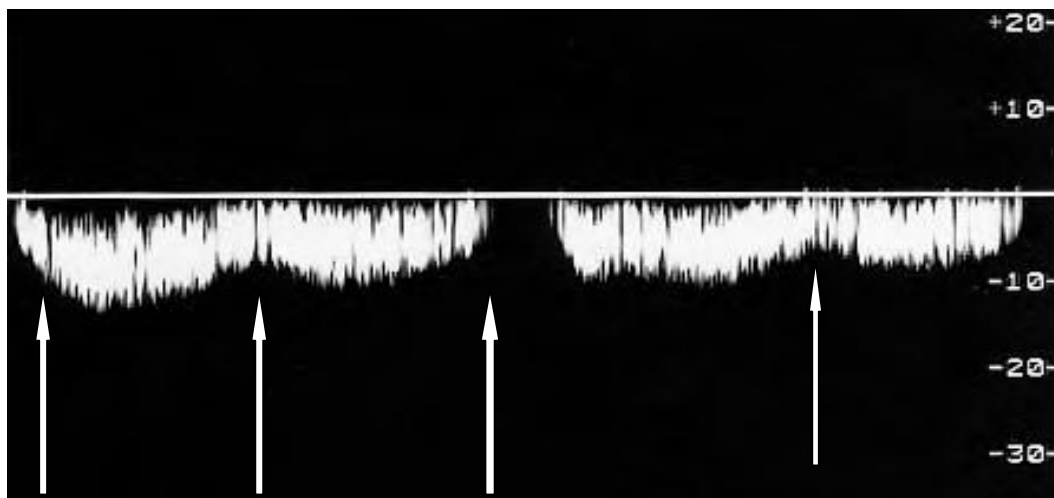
Doppler waveform demonstrating the effect of respiration on the blood flow in the common femoral vein. The large arrow indicates the cessation of flow during inspiration and the small arrows show small changes in flow due to the cardiac cycle, which may not always be seen in the common femoral vein. (How where and when and where Thrush & Hartshorne 2005 page No61)
